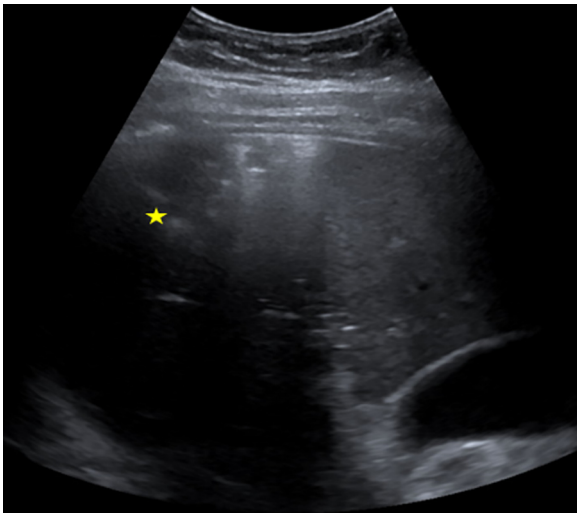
Ultrasound imaging of the liver. A 7 × 6 cm sized lesion surrounded by air in the right lobe of the liver became evident (marked by the yellow star).
